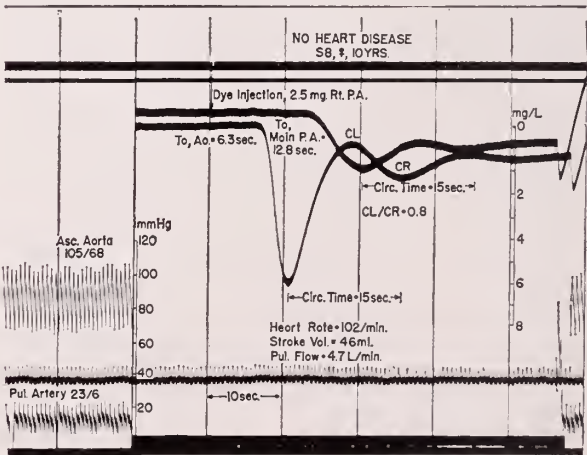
depicts the dye curves and other parameters of cardiac catheterization in the child without heart disease whose x-ray is shown in figure 2. (see text)
